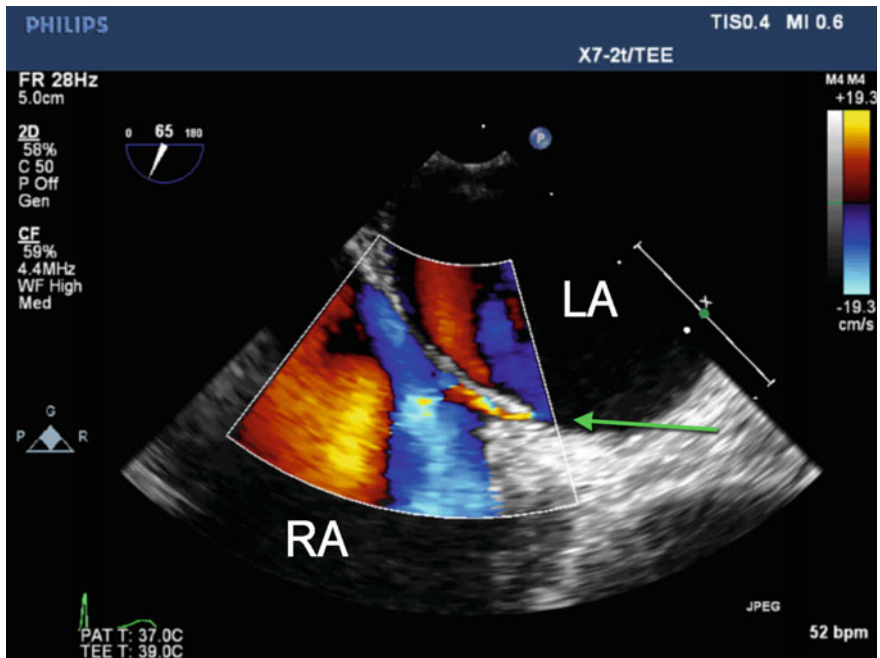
Midesophageal view of interatrial septum with color flow Doppler. The *green arrow* indicates a *left to right* shunt across a patent foramen ovale (PFO). LA left atrium; RA right atrium
